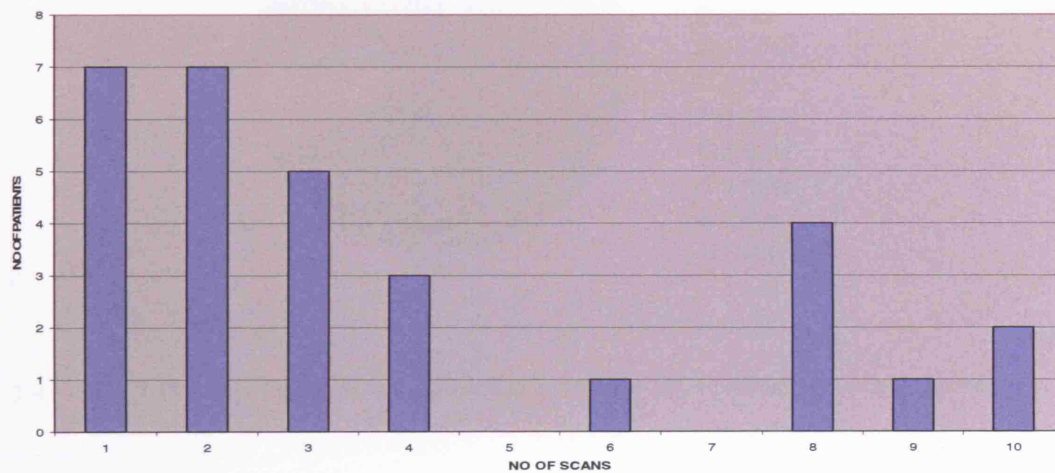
Number of patients undergoing specific numbers of MT MRI examinations prior to data quality assessment
